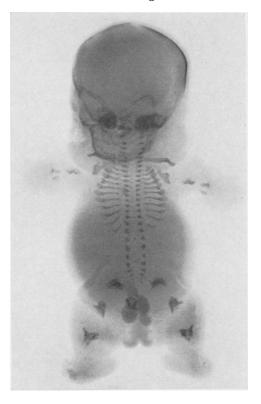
Front roentgenograms. Note almost complete absence of calcification in vertebral bodies
